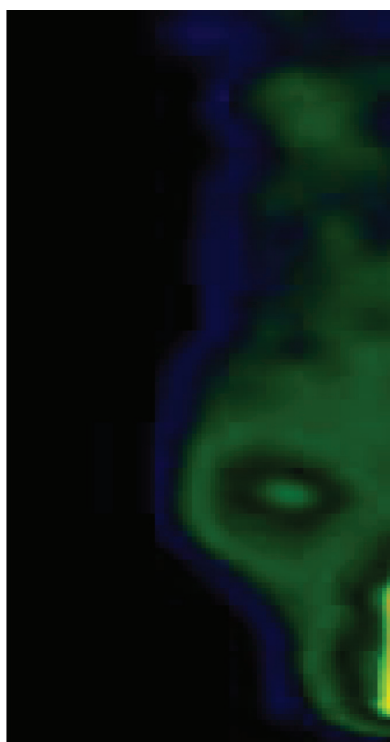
Octreoscan with 111-in-pentetreotide: the SPECT images showed a pathological focal uptake area in the right breast
